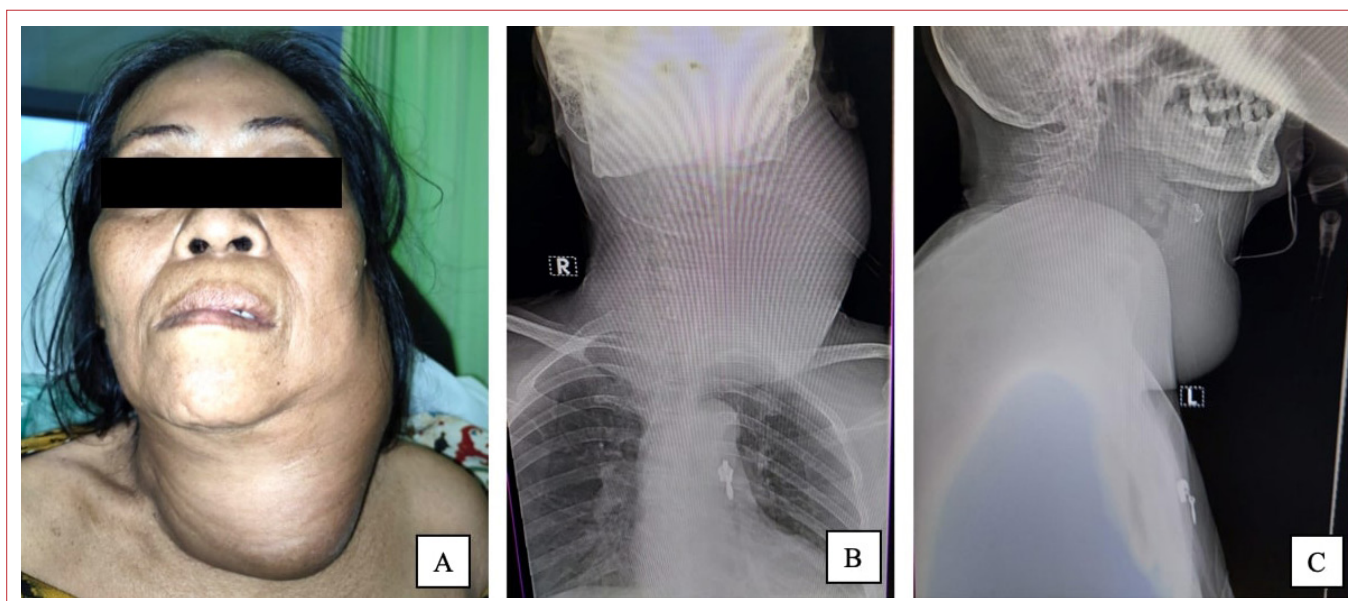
Clinical pictures and imaging of the patient before the procedure. (a) Front view of the cervical mass; (b) Anteroposterior cervical and chest X-ray showing an 11.3 x 19.6 cm cervical mass; (c) Lateral view of the cervical X-ray
